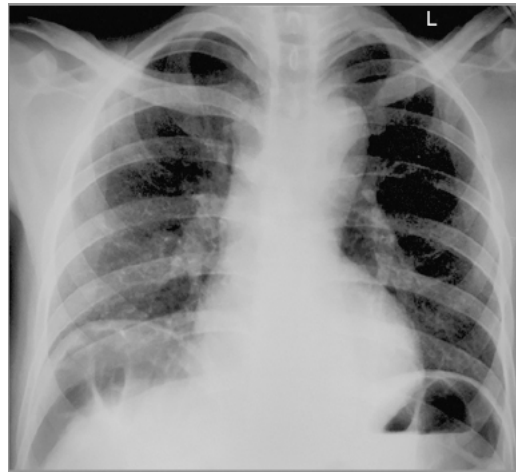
Chest X-ray PA view showing free air under bilateral hemidiaphragm—pneumoperitoneum.
